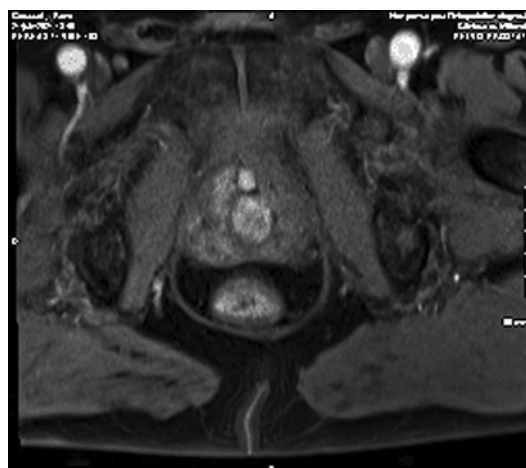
Axial T1-weighted gadolinium-enhanced fat saturation MRI image.
